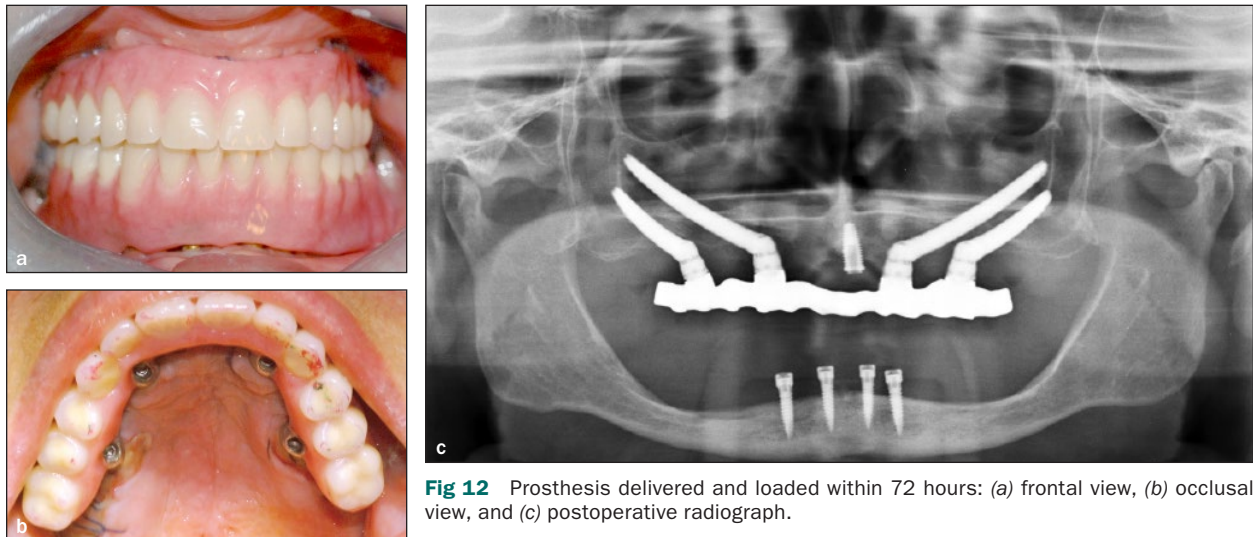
Prosthesis delivered and loaded within 72 hours: (a) frontal view, (b) occlusal view, and (c) postoperative radiograph.
